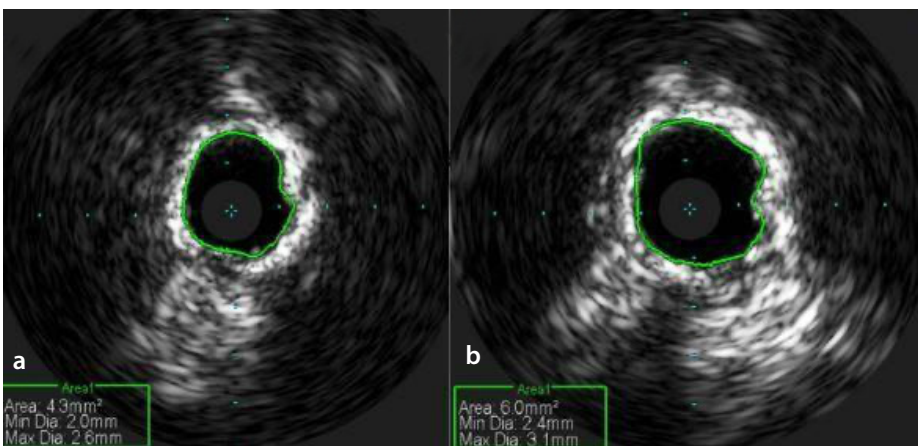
Measurement of minimum lumen diameter and area in intravascular ultrasound analysis of the calcified lesion in the mid segment of the posterior tibial artery before (a) and after (b) 3.5 mm balloon angioplasty.
